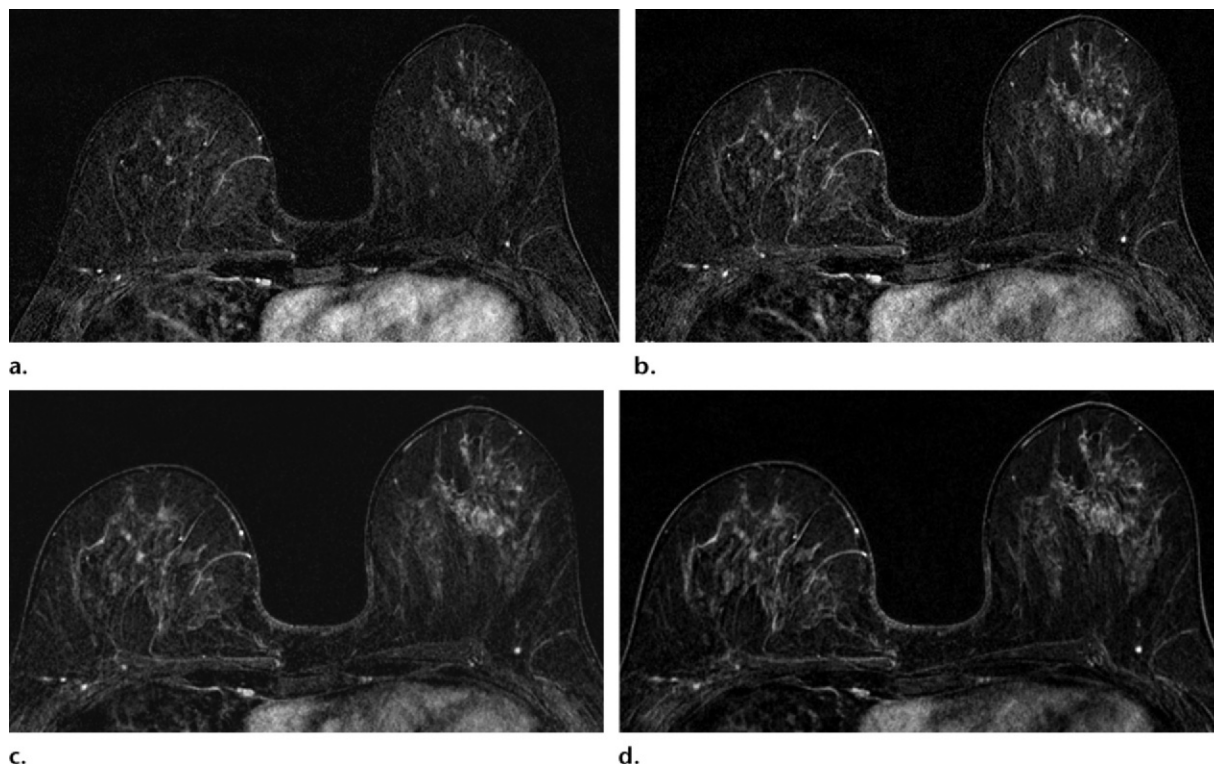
Axial contrast-enhanced dynamic T1-weighted MR subtraction images show typical BPE kinetic features with slow early and persistent delayed enhancement. Images are from the first contrast-enhanced series (a), second contrast-enhanced series (b), third contrast-enhanced series (c), and fourth contrast-enhanced series (d).
